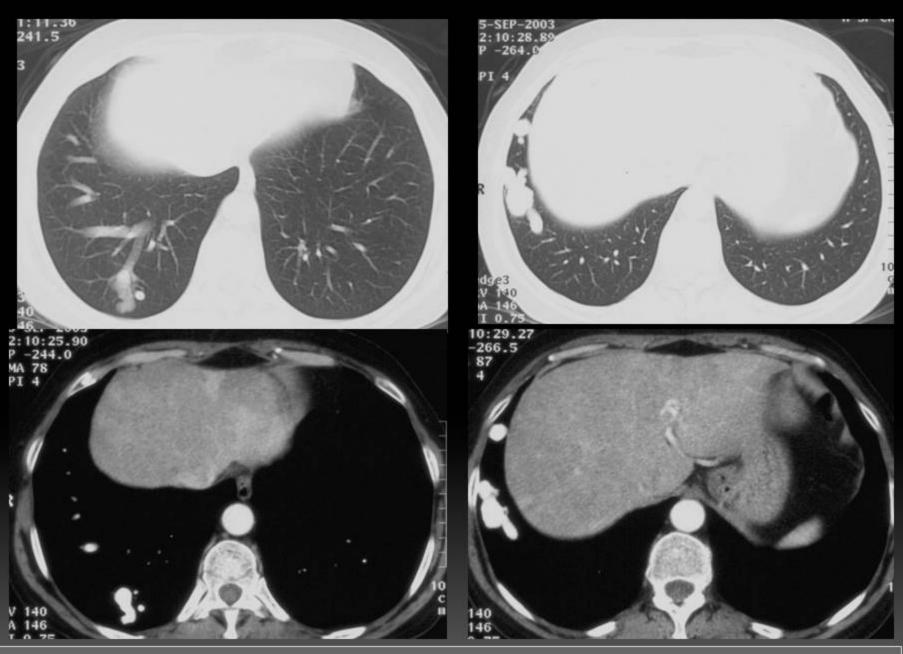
Man, 20 years old, with hemoptysis. Thoracic CT (axial planes) discloses multiple subpleural lobulated and well defined nodules in right lower lobe which strongly enhance after iv contrast, as well as aorta. First image shows a single dilated and tortuous feeding artery and vein in one of these nodules.
